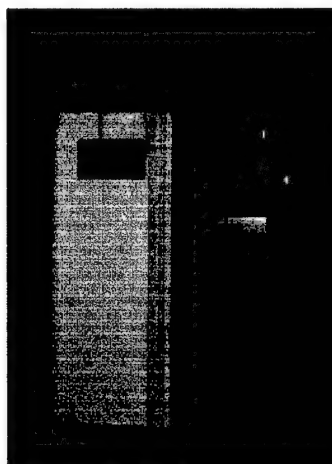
Portable ultrasound units. Left: Terason 2000 (Teratech Corporation); right: MUSTPAC
